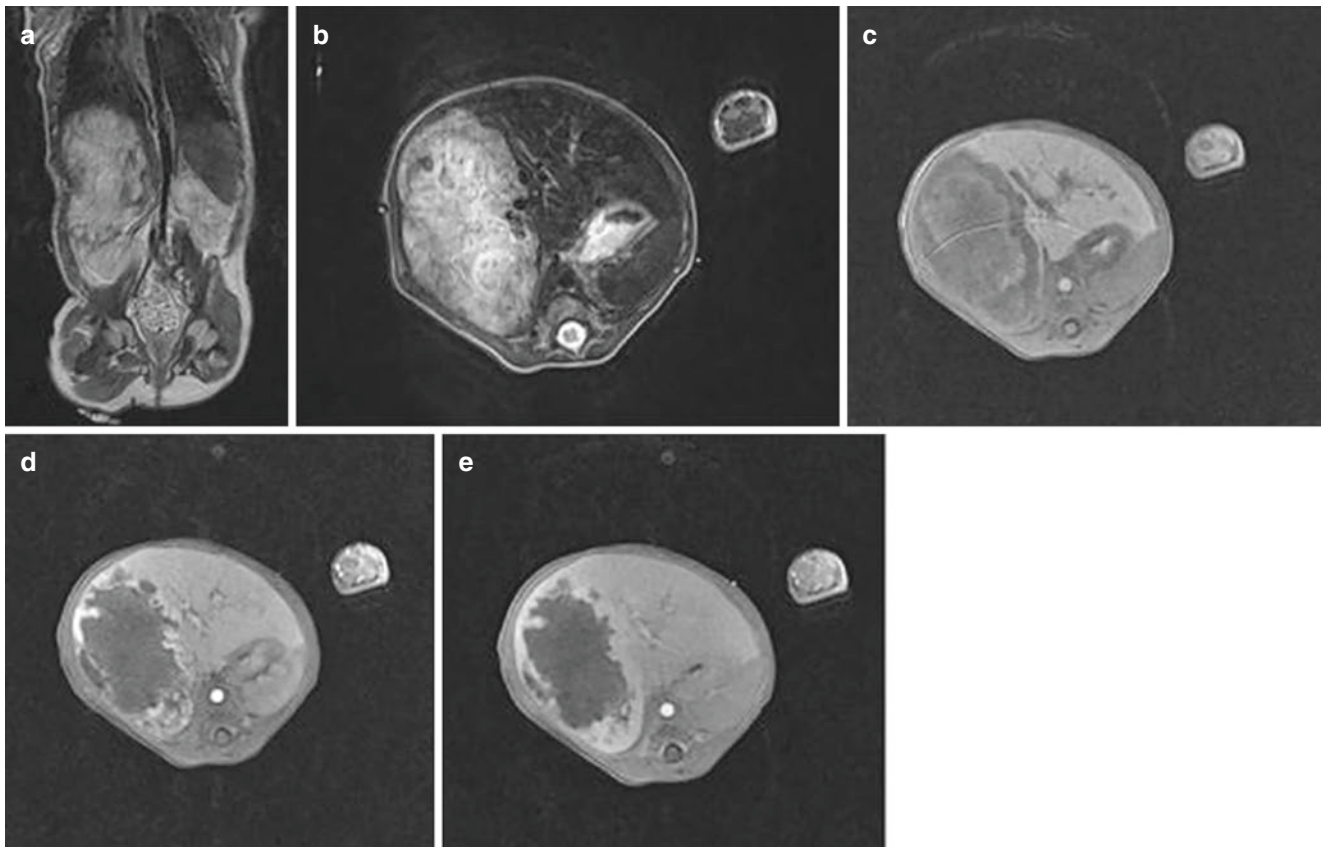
MRI findings in a 2-week-old infant with infantile hepatic haemangioma. Large, relatively well-demarcated exophytic mass in the *right* lobe of the liver ($81 \times 49 \times 87$ mm). There is heterogeneous hyperintensity on T_2 -weighted images with prominent flow voids (a, b). On non-contrast-enhanced T_1 -weighted images, the spontaneous hyperintense zones in the lesion are compatible with haemorrhagic components
